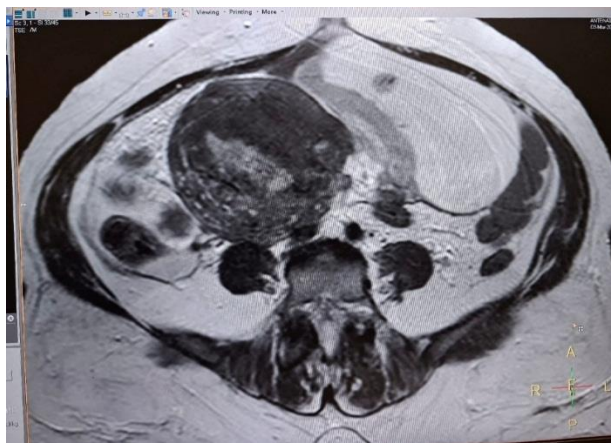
Pre-operative MRI showing a deformed fetus in an extrauterine location
